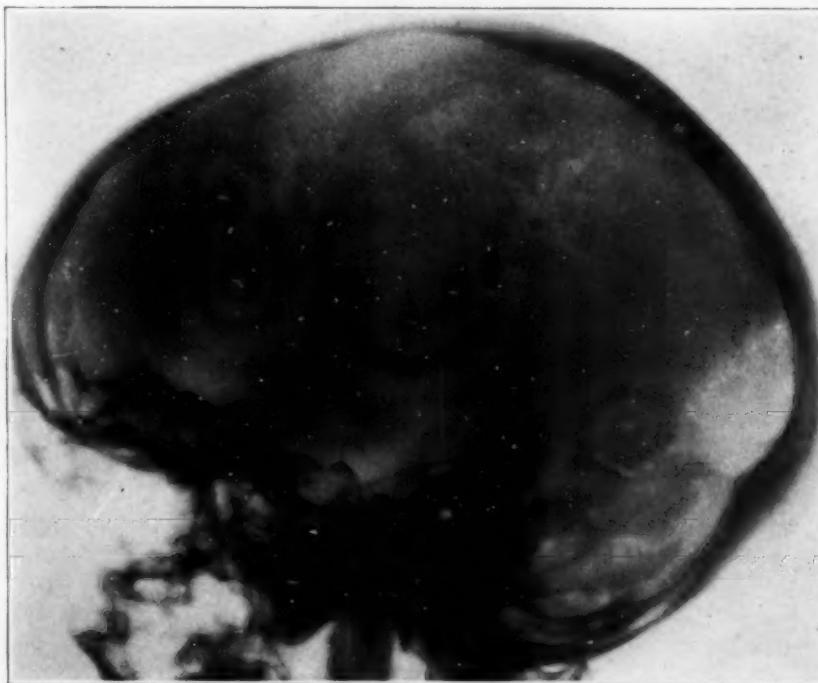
Roentgenogram of the skull to show the posterior temporal diploic vein and its branches; a picture frequently seen on roentgen-ray plates.
